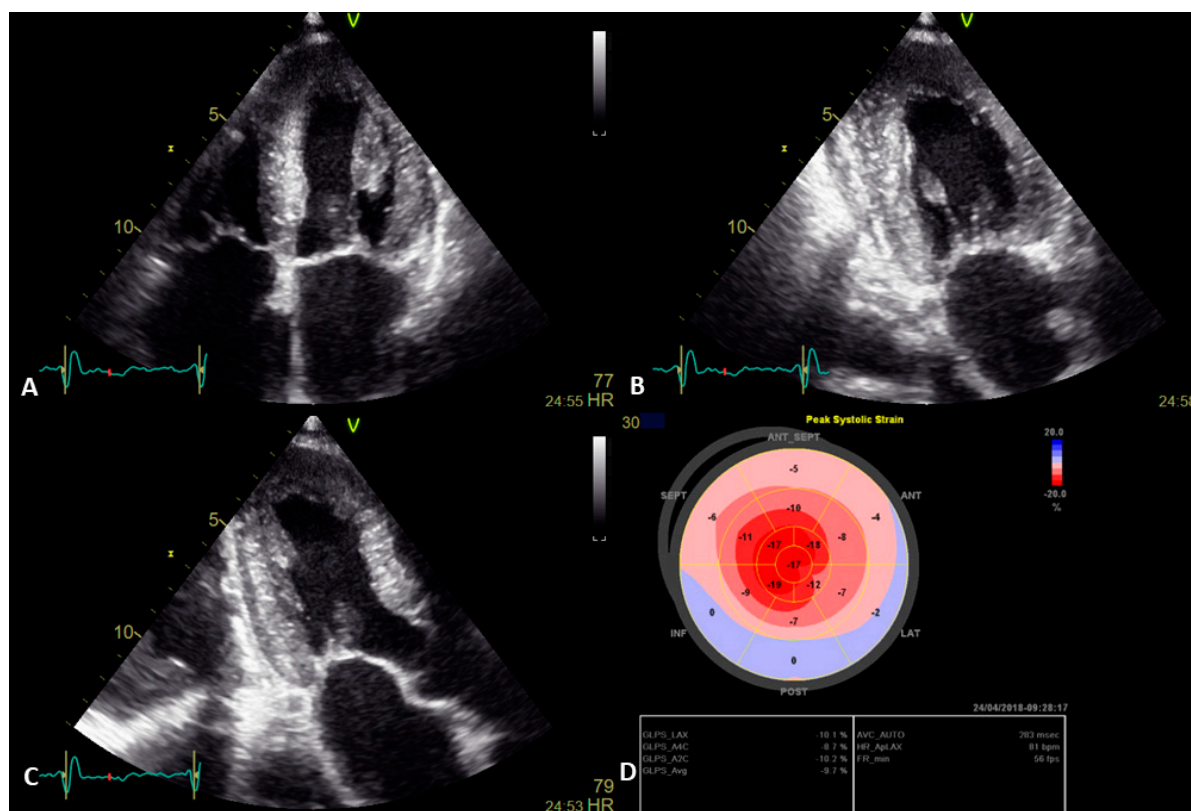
Global longitudinal strain in cardiac amyloidosis. Panels A, B, C show 2-dimensional apical four chamber-, two chamber, and three chamber view, respectively. In panel D, the strain map shows particular patterns suggestive of amyloidosis with relative preserved strain in apical segments and decreased on mid and basal level (apical sparing pattern).
